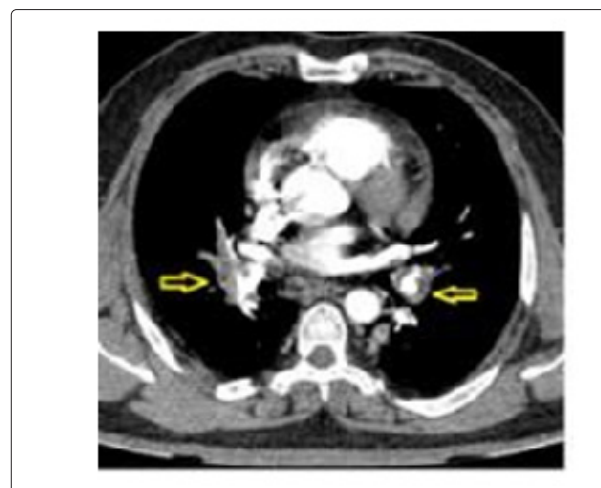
HRCT chest, axial section showing thrombosis of bilateral pulmonary arteries (arrows).
